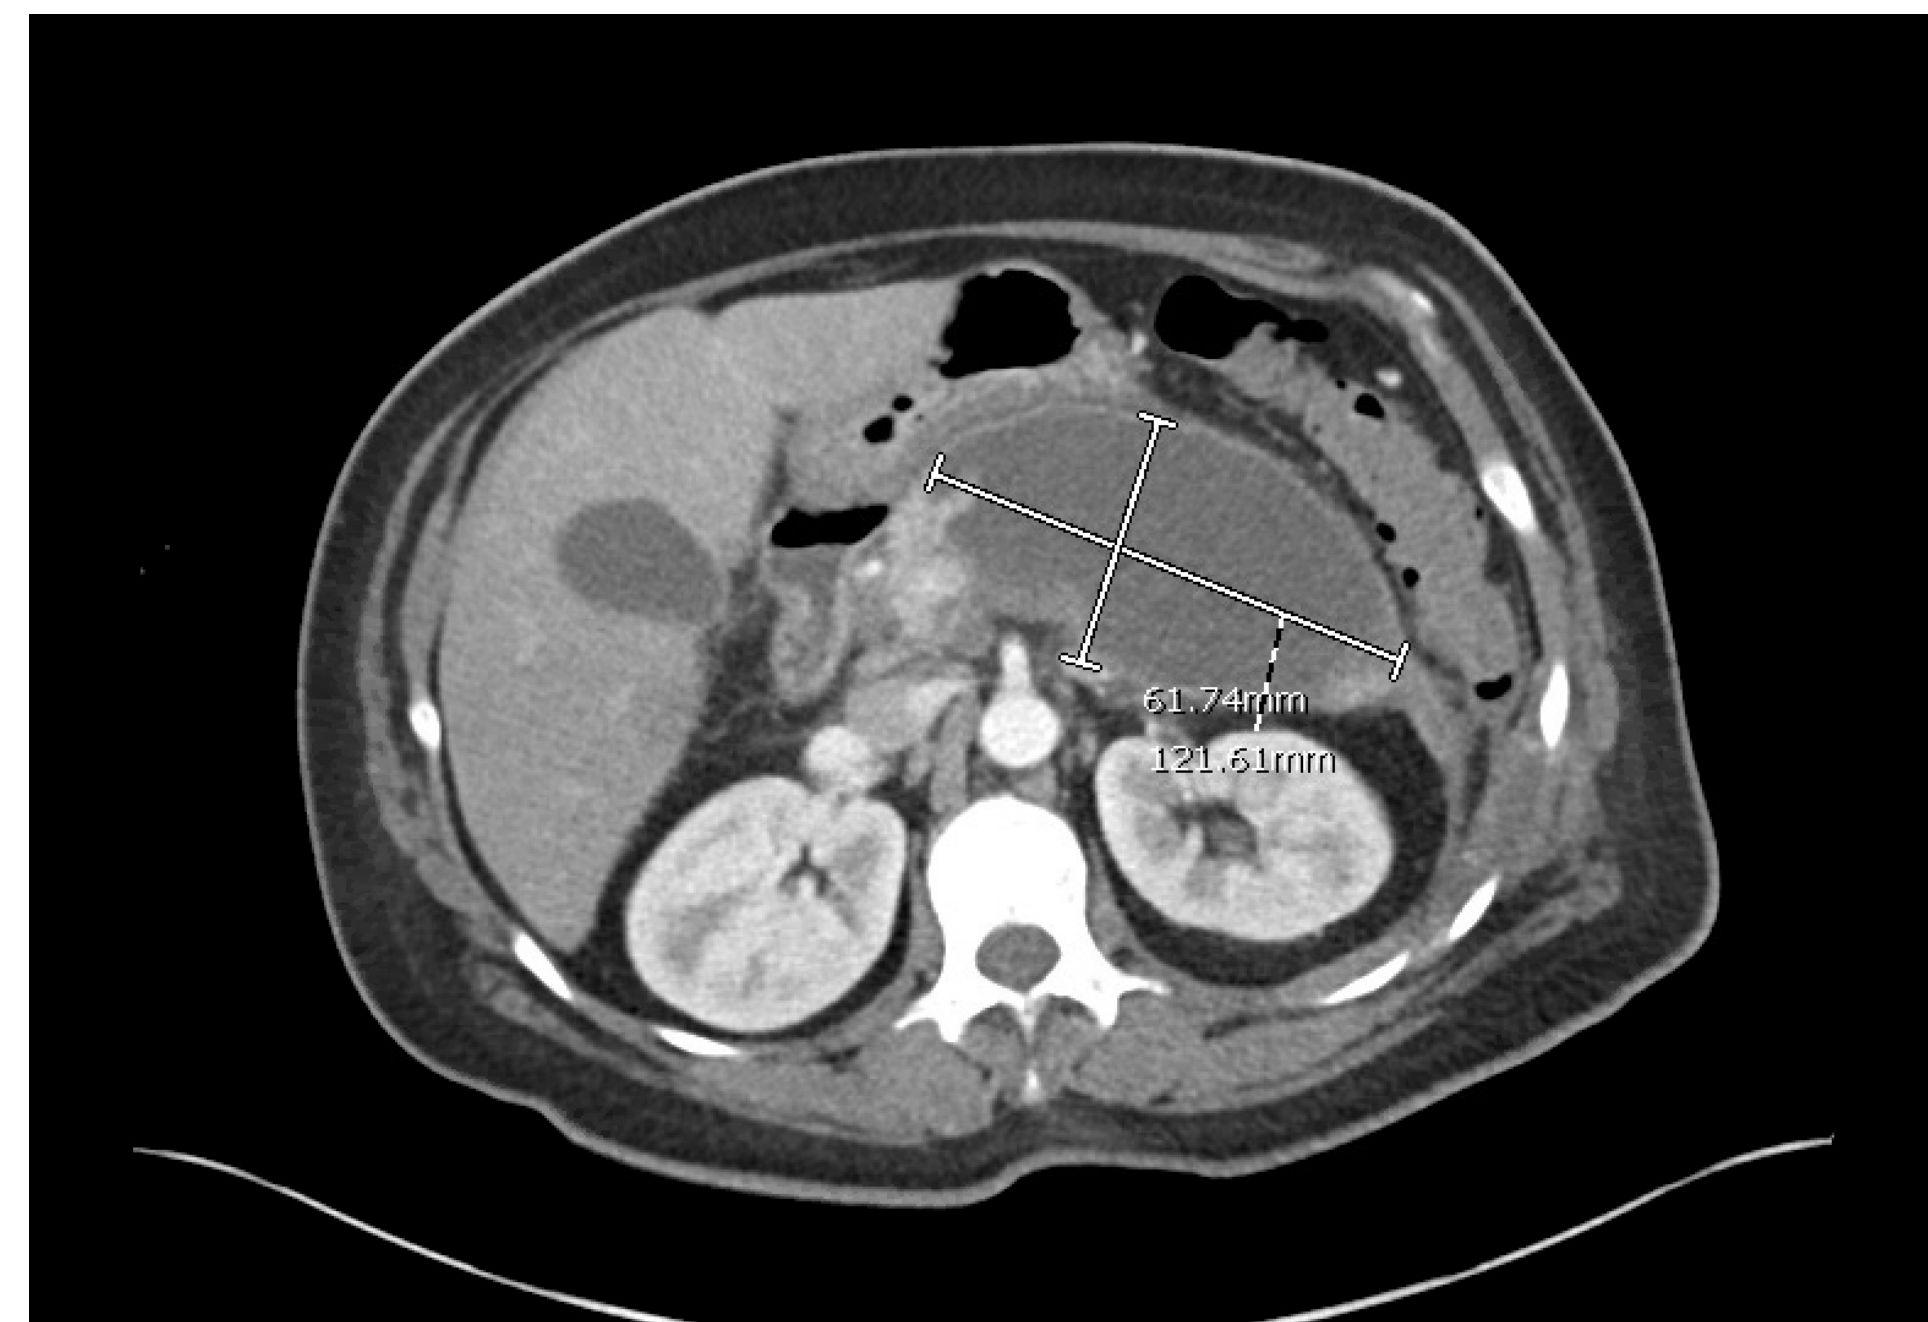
CT Abdomen and Pelvis w/ Contrast showing a collection replacing the majority of the pancreatic body
